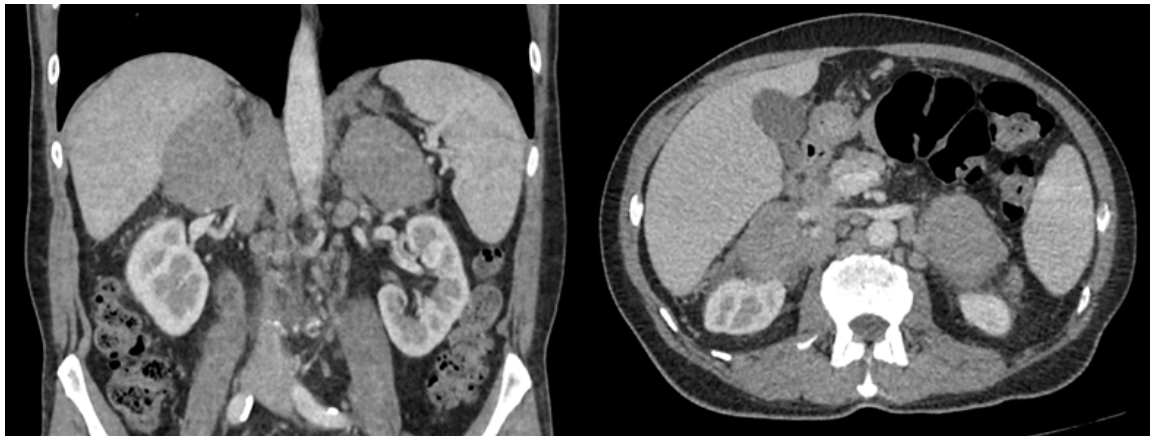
Coronal and axial slices, soft-tissue window, 1.25 mm thickness, contrast-enhanced CT.
